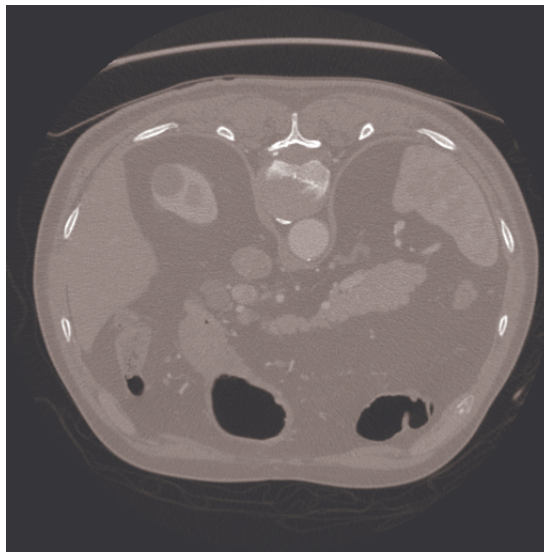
Example of CTA scan
